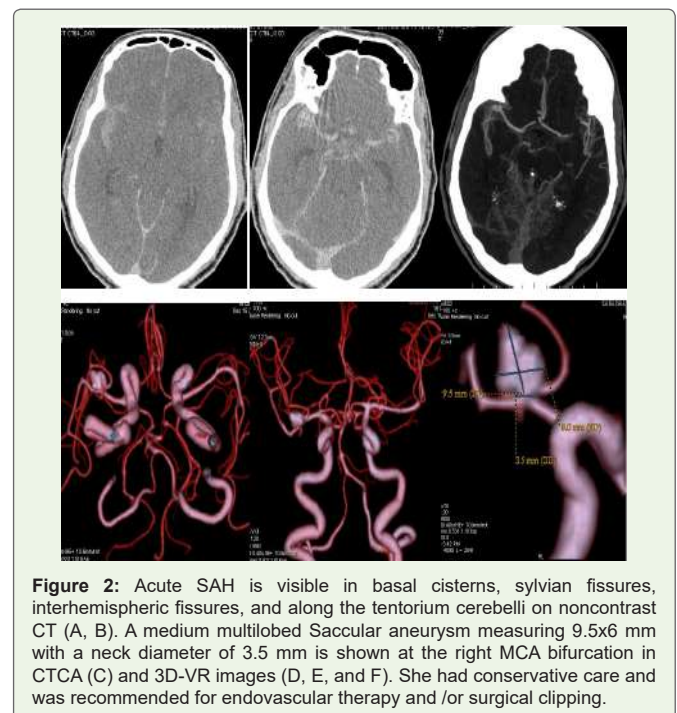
Acute SAH is visible in basal cisterns, sylvian fissures, interhemispheric fissures, and along the tentorium cerebelli on noncontrast CT (A, B). A medium multilobed Saccular aneurysm measuring 9.5x6 mm with a neck diameter of 3.5 mm is shown at the right MCA bifurcation in CTCA (C) and 3D-VR images (D, E, and F). She had conservative care and was recommended for endovascular therapy and /or surgical clipping.
